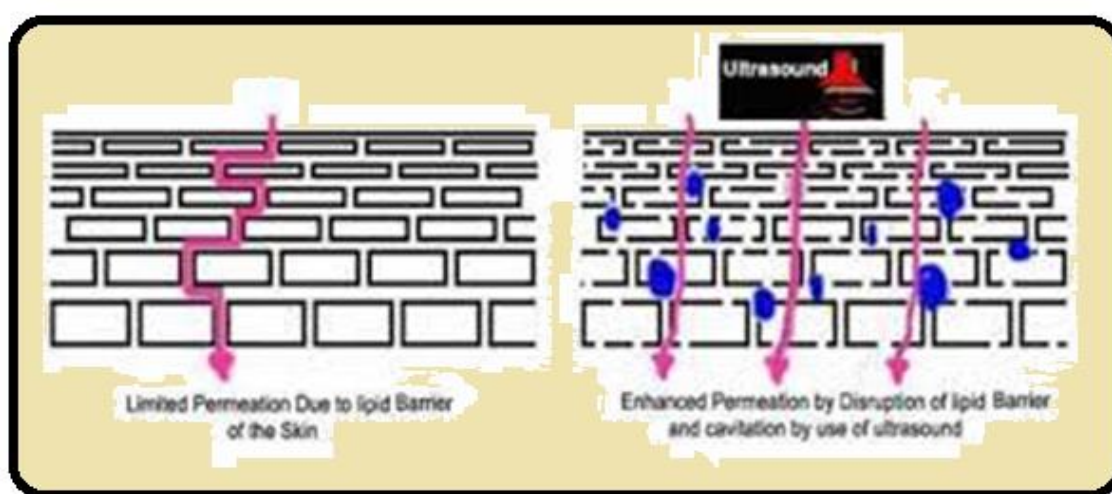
Enhanced transdermal permeation by cavitation upon application of ultrasound⁵⁷.
